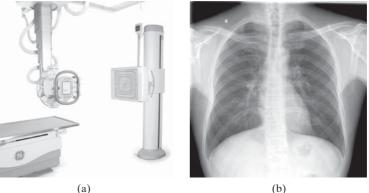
(a) A chest x-ray unit and (b) a chest x-ray image.
